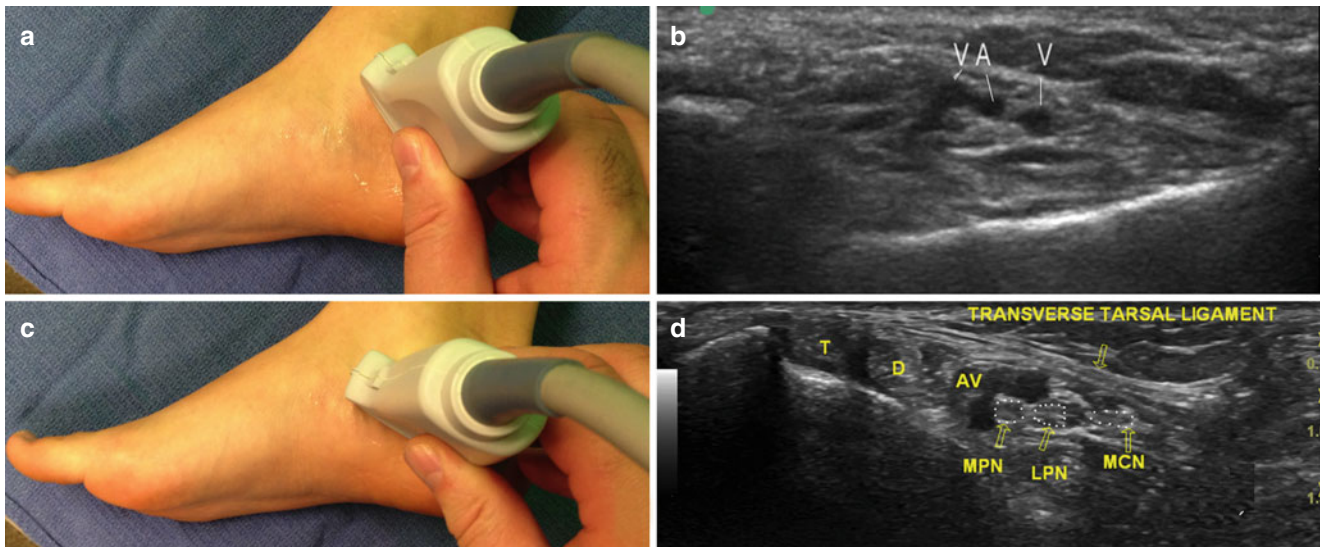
Ultrasound localization of the plantar nerves. (a) Proximal tarsal tunnel ultrasound probe placement; (b) ultrasound image of the proximal tarsal tunnel (A artery, V vein); (c) ultrasound probe placement to show the plantar nerves as they enter the distal tarsal tunnel; (d) ultrasound identification of the plantar nerves; T posterior tibialis
